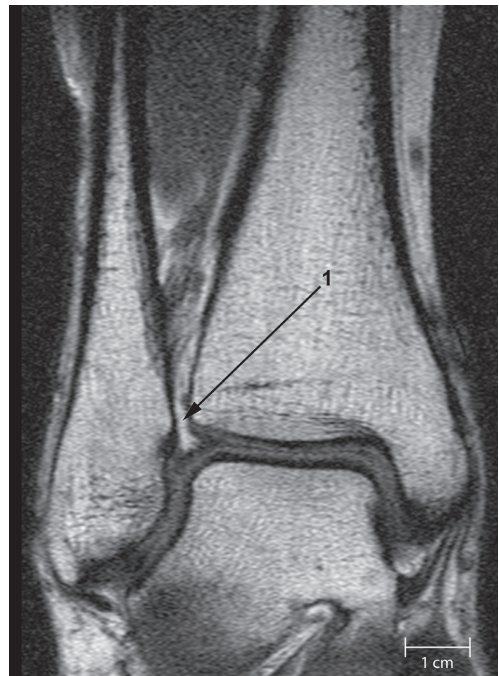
Coronal proton-density-weighted MR image (female, 23 years).The fat-containing synovial fold (1) protrudes from the incisura fibularis into the lateral superior tibiotalar joint space. During dorsal flexion of the foot, the talus pushes the tibia and fibula outwards, therewith increasing the space of the tibial incisura. This leads to retraction of the fatpad, as can be seen during arthroscopy.
